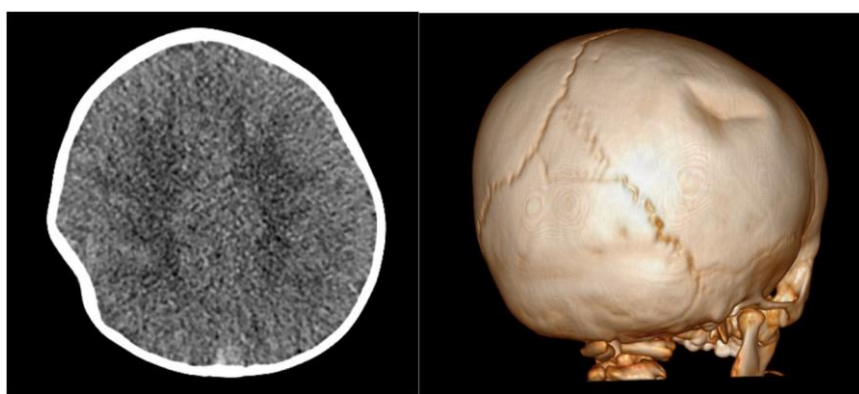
CT scan of a 10-month-old male infant showing a depressed parietal skull fracture associated with focal subarachnoid hemorrhage following an accidental fall from a changing table. The patient underwent surgical elevation of the depressed fracture.
